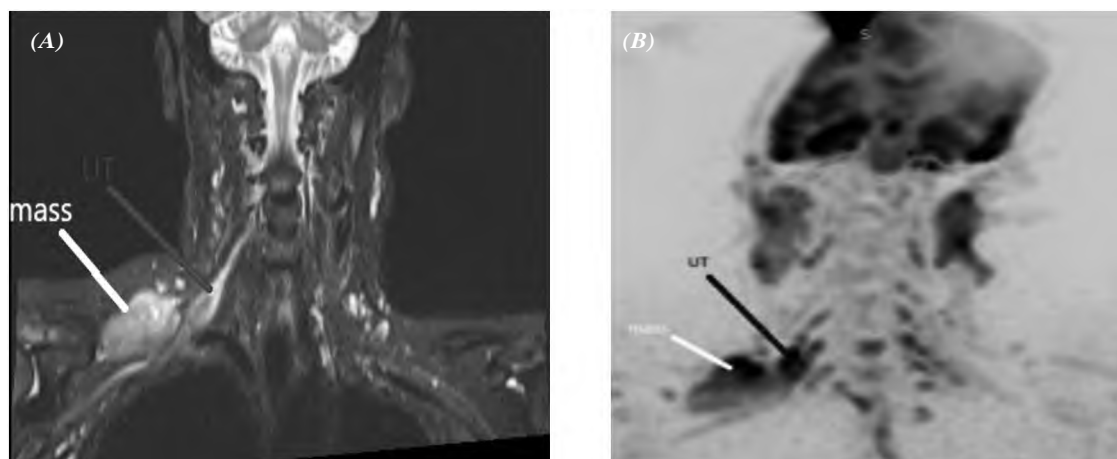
Female patient 49 years old complained from breast cancer with right upper limb pain of 1 year duration, (A): Coronal 3D STIR SPACE, (B): Coronal DWI showing soft tissue mass lesion compressing the right brachial plexus upper trunk with thickened edematous upper trunk with restricted signal in DWI.
